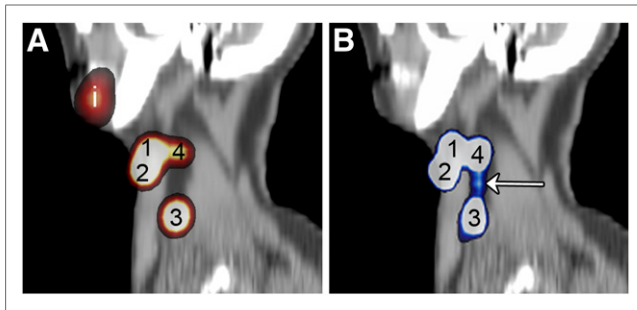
(A) Sagittal SPECT/CT image of patient 2, obtained 30 min after injection of ^{99m}Tc -nanocolloidal albumin, showed 4 hot spots of which 3 (1–3) were identified as SN and 1 (4) was identified as second-echelon lymph node due to lower uptake in this lymph node. (B) Sagittal PET/CT scan image of same patient in which same draining lymph nodes could be visualized. On this image (frame 3 of dynamic scan, i.e., obtained 30–45 min after injection of ^{89}Zr -nanocolloidal albumin), connecting lymphatic vessel (arrow) could be identified by increasing intensity of PET images, which clearly demonstrated that lymph node in level III (3) was also second-echelon lymph node instead of SN. i = injection site.
